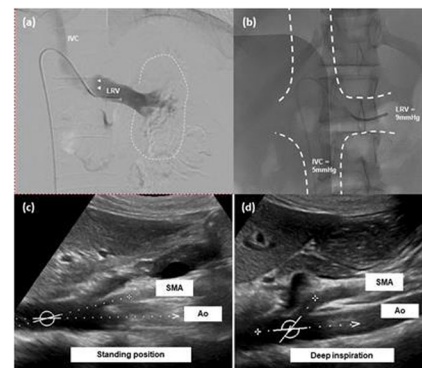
(a) Diagnostic venogram showed an abnormal indentation at the aortomesenteric portion of left renal vein (LRV) (white triangles) and slowing of contrast flow into more proximal portion of LRV (Left kidney outline annotated by white dash line). (b) Venous pressure at IVC was 4mmHg and that at distal LRV was 9mmHg. The pressure gradient between LRV and IVC was thus 5mmHg. (c) Dynamic ultrasound performed at standing position showed narrowed aortomesenteric angle (13.8°, normal = 38–65°) and (d) with deep inspiration showed normal aortomesenteric angle measuring 47.0°.
